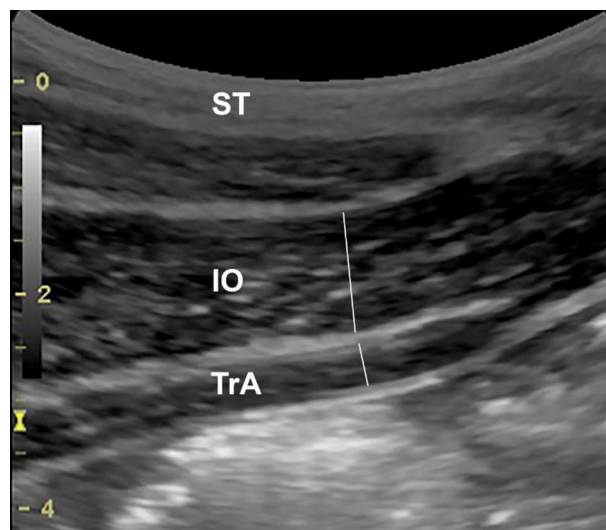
Ultrasound image of the right antero-lateral abdominal musculature. Parasagittal ultrasound image of the antero-lateral abdominal muscles with linear thickness measurements of the transversus abdominis (*TrA*) and internal oblique (*IO*) muscles taken at rest. *ST* subcutaneous tissue
